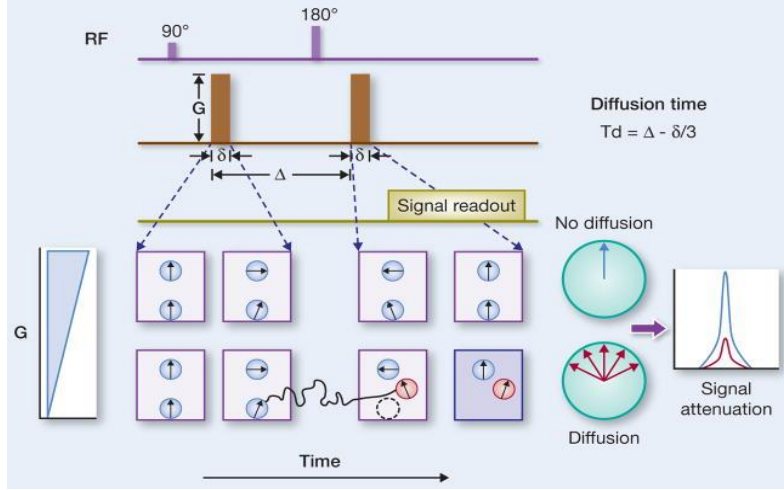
Diffusion weighted images are acquired by using additional pairs of gradient pulses with magnitude G and duration δ . During the first pulse, protons are phase-encoded, depending on their spatial location. The second gradient, which realigns stationary spin phases, is applied after delay-time Δ . Imperfect refocusing occurs when water molecules diffused to another spatial location along the gradient field direction. This results in phase dispersion, which causes attenuation of the magnitude signal. T_d : effective diffusion time. Adapted from “Role of diffusion weighted MR imaging in characterization of focal kidney and upper urinary tract lesions”, by ‘D. M. Sobh et al.
